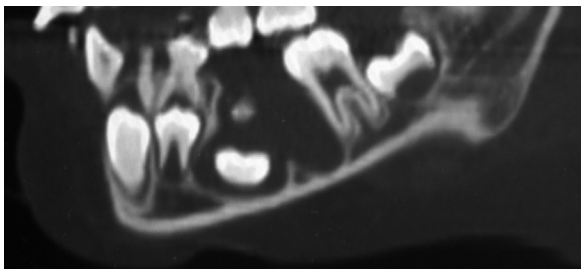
Sagittal computed tomography showed calcified masses above the unerupted tooth in the well-circumscribed lesion.
